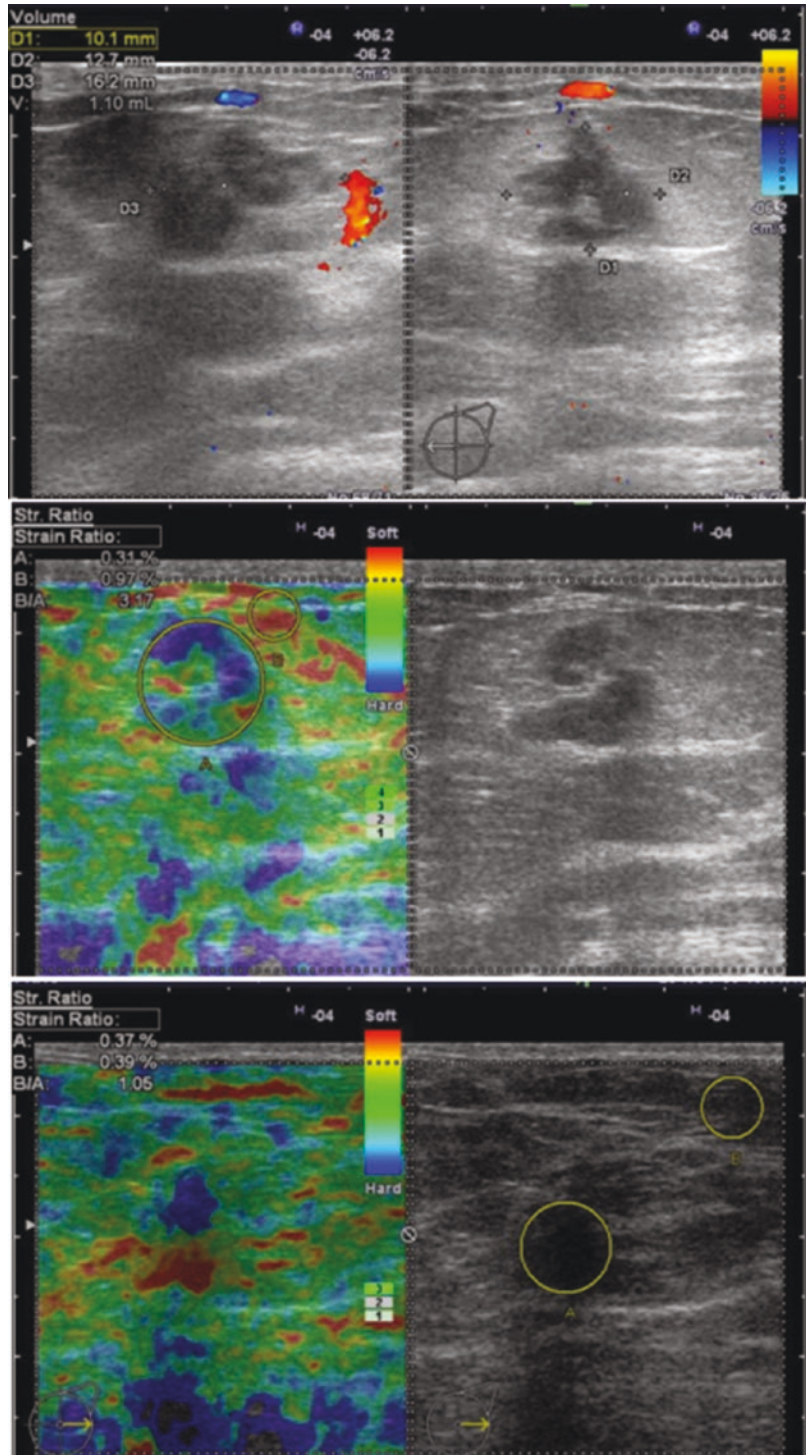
Inspissated cyst, the differential diagnosis with a solid mass: the absence of any Doppler signal together with a BGR score, whatever the protein content of the cystic fluid
